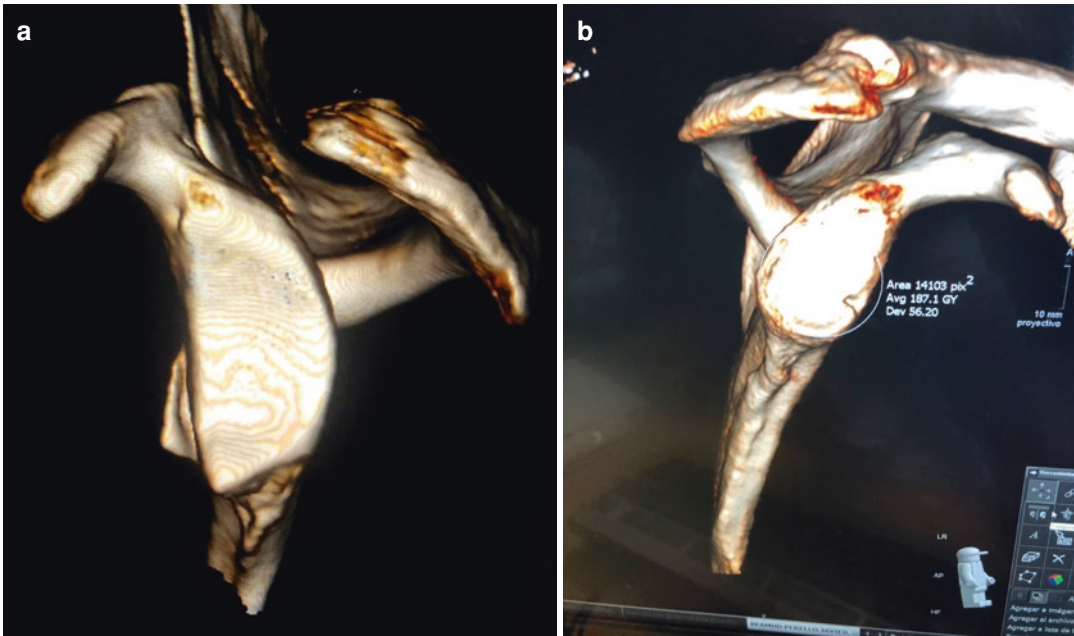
Glenoid defects are best studied using 3d-CT reconstructions in the “en face” view. Two examples can be observed: a patient with a critical glenoid bone defect <25% (a) and a patient with a subcritical bone defect (b)
